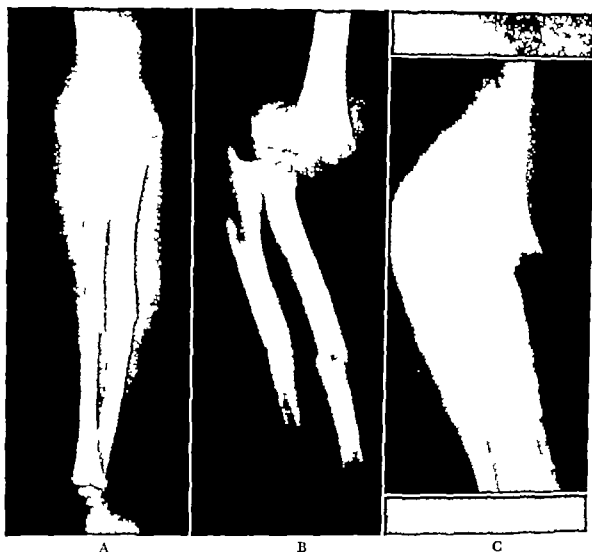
Supracondylar fractures of humerus with marked displacement of distal fragment and associated injuries. (A) and (B) Antero-posterior and lateral roentgenograms of a six year old boy showing associated fractures in middle third of shafts of radius and ulna. This patient's elbow was treated by Kirschner wire skeletal traction and the forearm fractures by molded plaster splints. (C) View of elbow in another boy eight years of age in which the distal fragment of the humerus is displaced so far posteriorly that the lower end of the shaft perforated the skin creating an open (compound) fracture. Kirschner wire skeletal traction and suspension were also used in this patient to maintain reduction of the fragments after thorough surgical debridement and cleansing of the contaminated wound.
